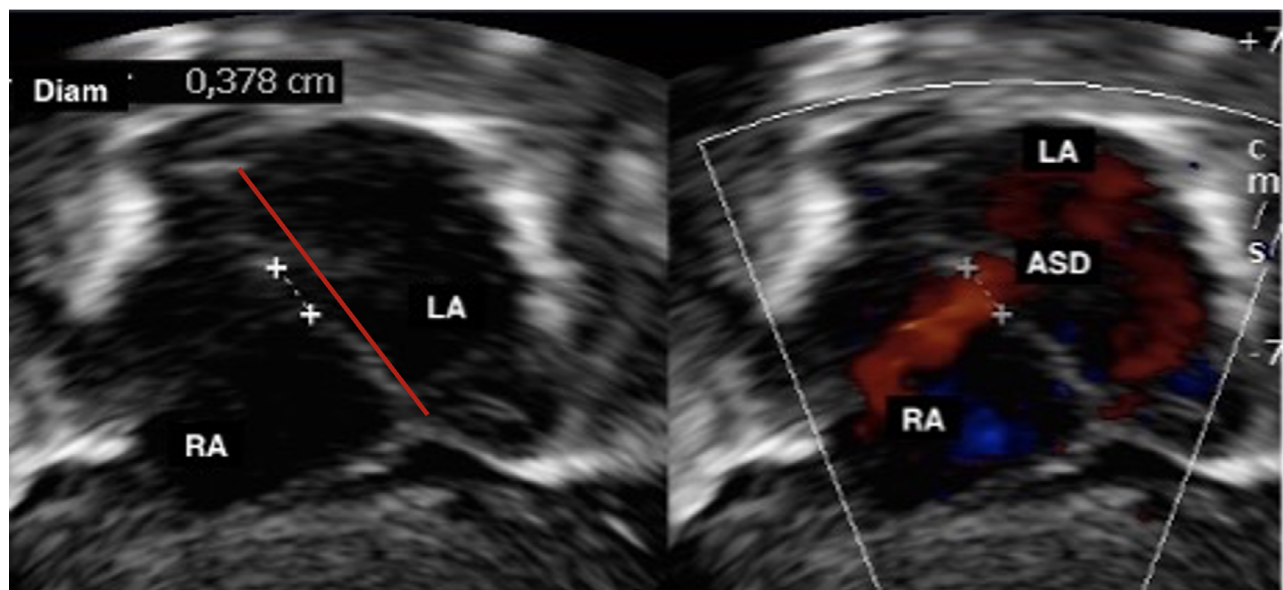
two-dimensional echocardiogram in the subcostal view showing ASD. Red line: septum diameter. Dashed line: ASD diameter.
